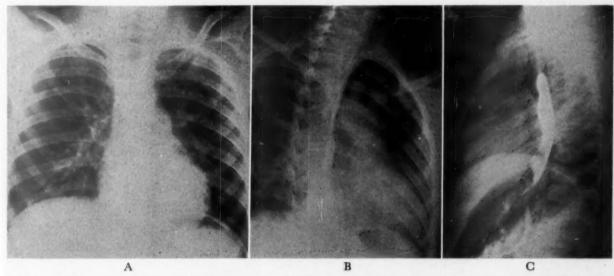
Case 17. Roentgenograms in the posteroanterior (A), right anterior oblique (B) and left anterior oblique (C) positions indicating slight increase in pulmonary vascularity, questionable left ventricular enlargement and slight but definite left atrial enlargement (B and C).
